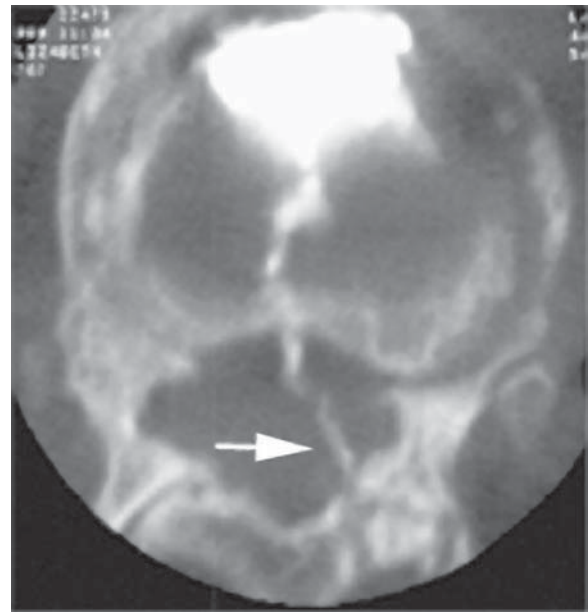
During vertebroplasty of T12, the patient experienced severe back and leg pain followed by bilateral hip flexor weakness. Spiral CT scan shows the needle track through the left T11 lamina and spinal canal and into the T11–T12 disc space, where the majority of the cement had been deposited. The cement decompressed along the needle track and was applied to the lateral aspect of the conus (arrow). MR (not shown) did not show cord edema, but tenting of the conus against a fracture fragment may have been responsible for the neurological deficit.
